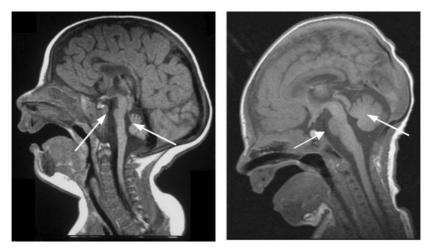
Magnetic resonance image of a child with PCH2 (left) compared to a normally developed child (right); the arrows show the underdeveloped pons and cerebellar vermis (short arrows) (Sanchez et al.)
